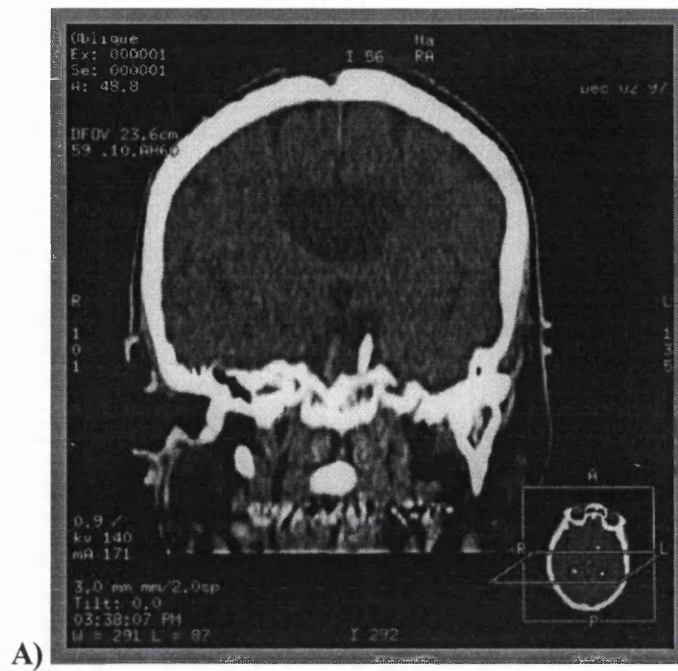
The pre-operative CT scans from IGN case 4 show how the ventricular catheter had migrated through the ventricular wall, coming to lie in the interpeduncular fossa. A) Coronal and B) sagittal views.
